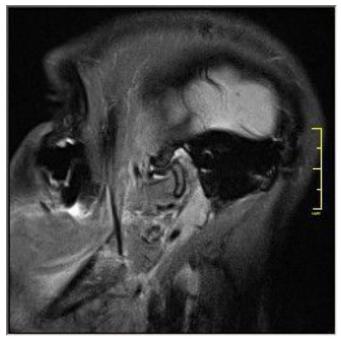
MRI signs of hematoma, deformity and penetration of the capsule
